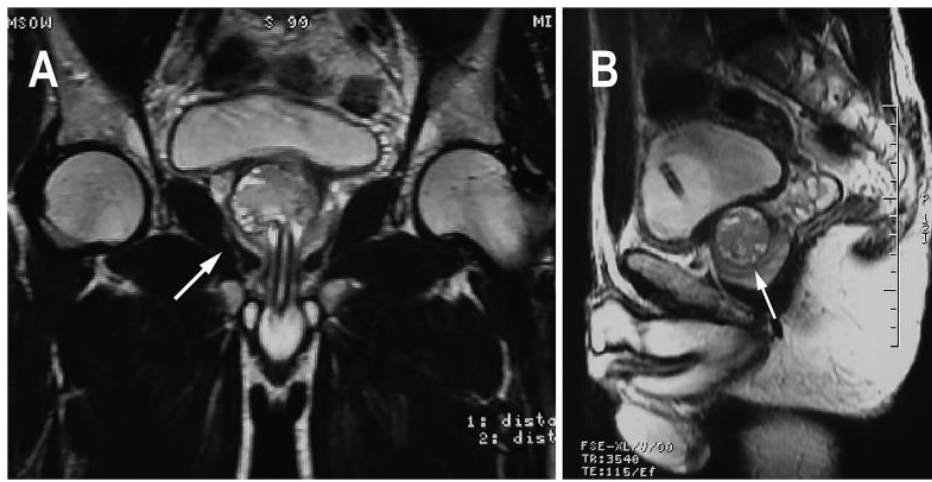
Abdominal-pelvic magnetic resonance imaging revealed a round 2.5-cm diameter mass lesion in the prostate. A: coronal view B: sagittal view. Reproduced from: [1] under the Creative Commons Attribution License.
